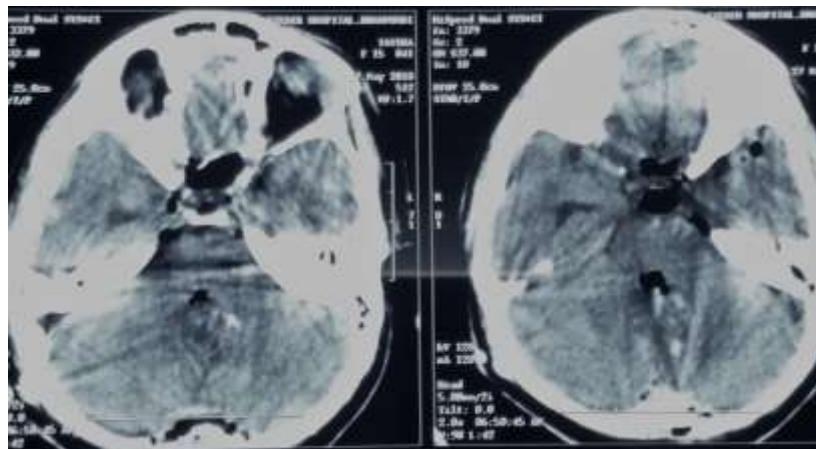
Post-operative CT brain shows near total excision of tumor with postoperative pneumocephalus
